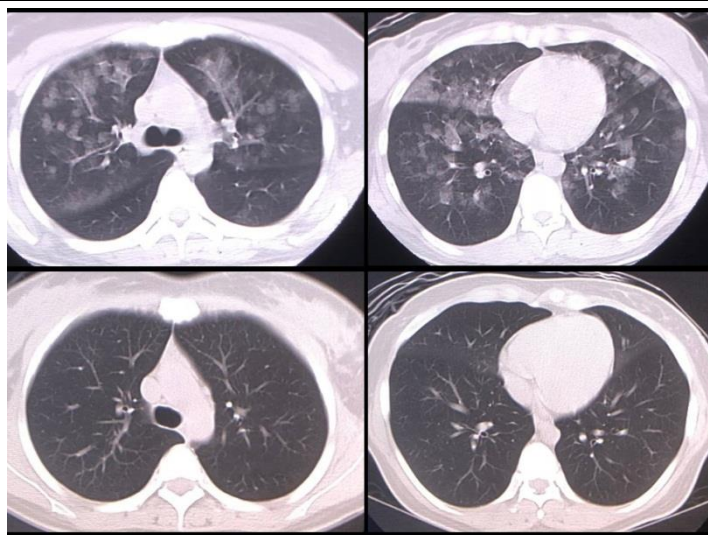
Thoracic computed tomography (upper, on arrival; lower, the third hospital day). Thoracic CT on arrival showed a bilateral ground-glass appearance in the lung fields. On the third day, the findings in the lung fields became normal
